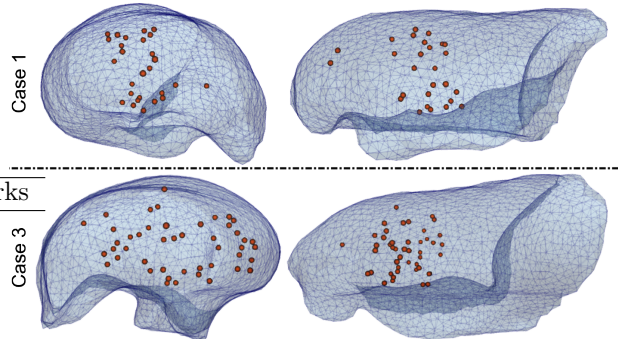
Spatial distribution of anatomical landmarks within the lung FE mesh reconstructed from the preoperative CT image.
